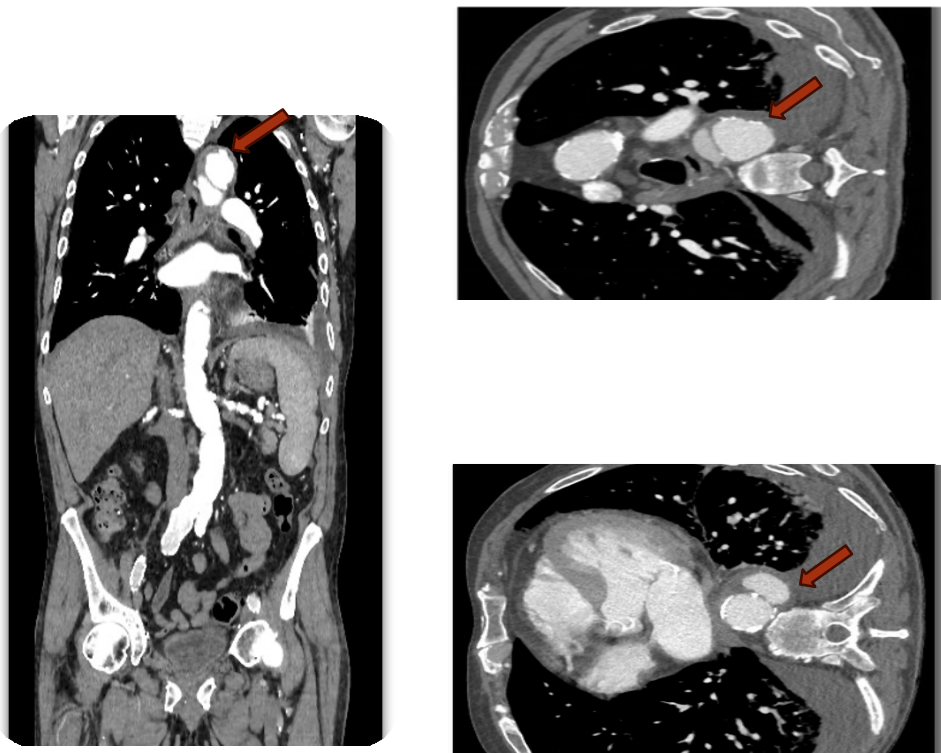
TA CT scanner: Type B aortic dissection with ulcerations.
